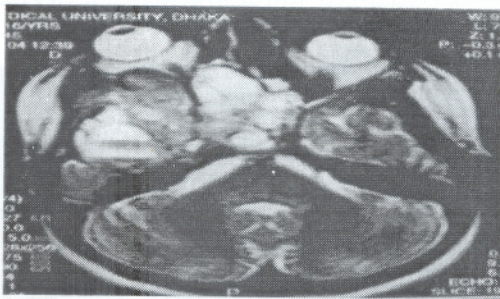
Axial T2W MR image of brain shows heterogeneous hyperintensity mass lesion having fluid fluid levels.
